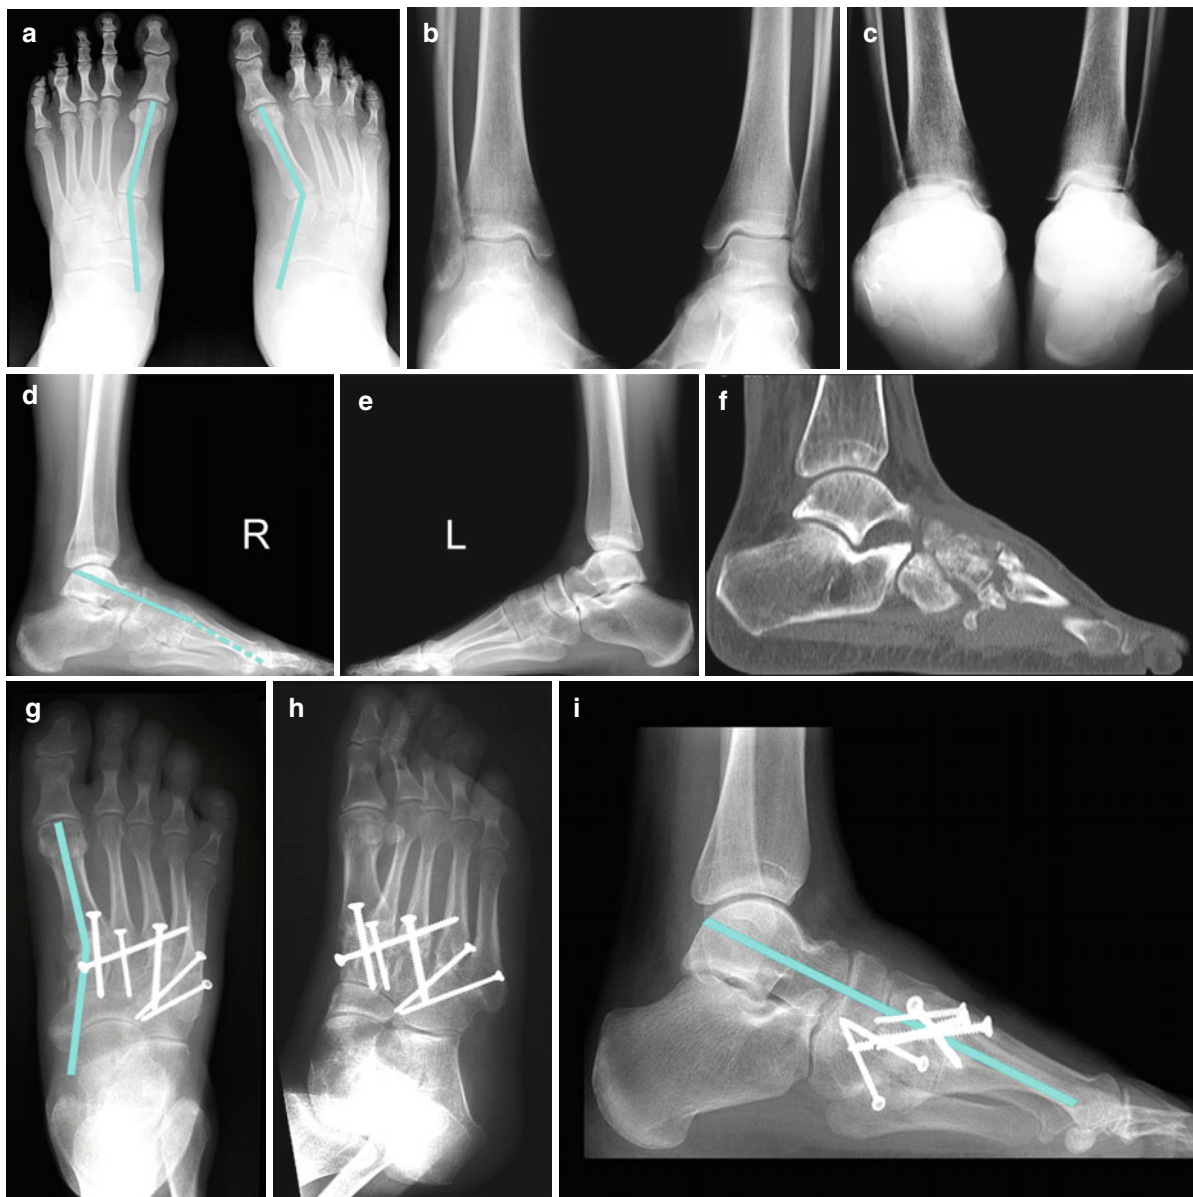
Severe arthritis of the right Lisfranc joint resulting from joint incongruity (a, d, f) 1 year after homolateral Lisfranc dislocation fracture treated initially with minimally invasive K-wire osteosynthesis. Weight-bearing X-rays show an adduction deformity of the right foot in the dorsoplantar view (a), and a dislocated talometatarsal axis (*lines* in a and d) in comparison to the uninjured contralateral foot (e). Saltzman
